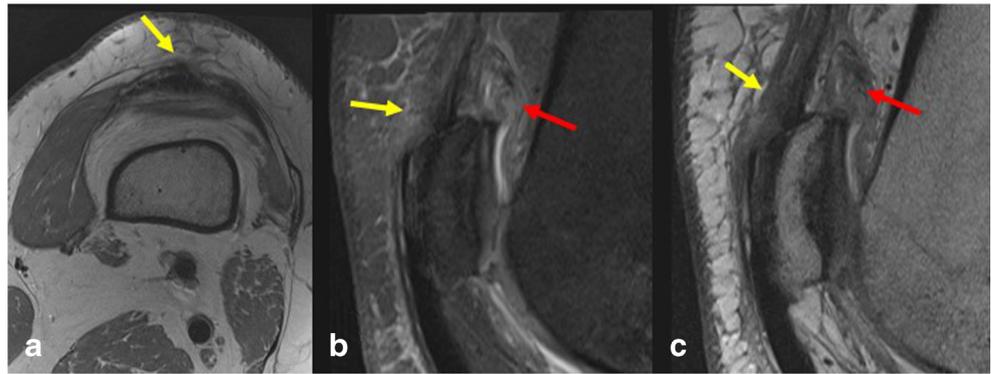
Full thickness graft harvest with defect closure and capsular repair. a Axial proton density, b sagittal proton density fat saturation MRI, and c sagittal proton density MRI demonstrating scar changes (yellow arrows) at the quadriceps tendon donor site with evidence of capsular rupture repair (red arrows)
